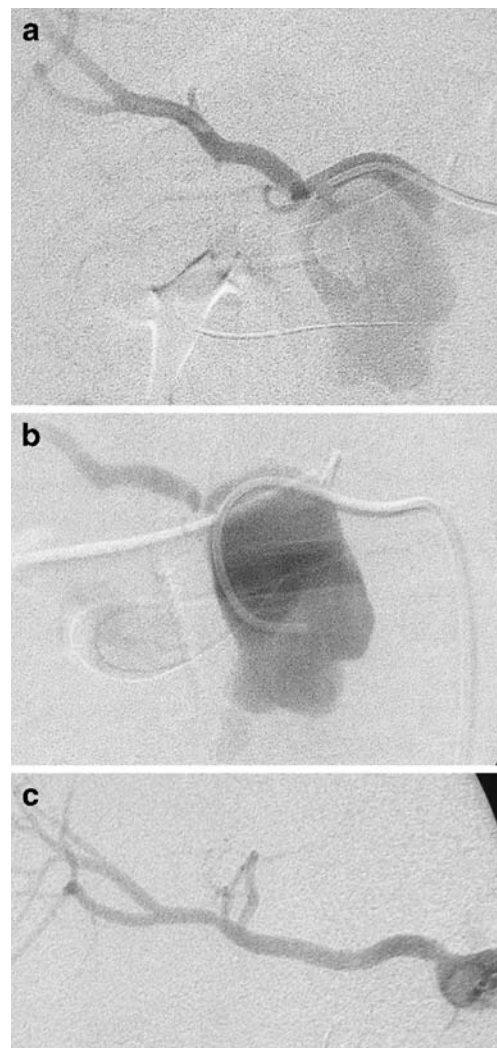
Arteriography performed on Patient 8. Following a sentinel bleed on Day 11, this patient presented with a new hemorrhage on Day 23. CT scan could not localize the origin. a Visualization of the common hepatic artery (CHA) and of a pseudoaneurysm of the gastroduodenal artery. b The catheter is in the pseudoaneurysm. c Placing a covered stent in the CHA, excluding the pseudoaneurysm and preserving hepatic inflow.
